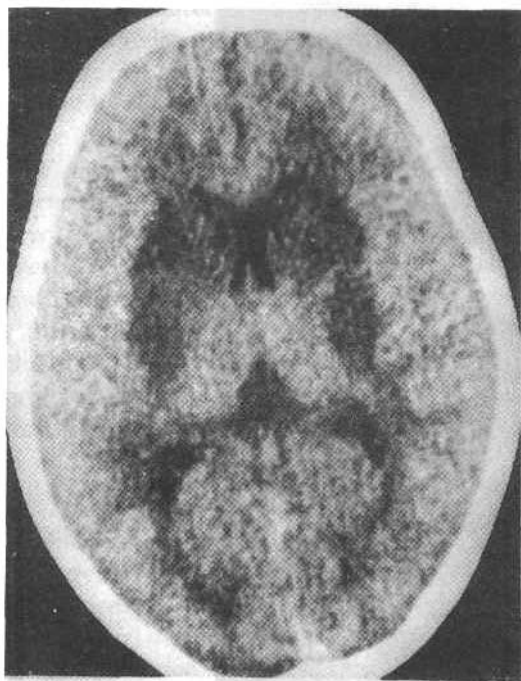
CT scan showing bilateral low density lesions of the caudate and putamen.
